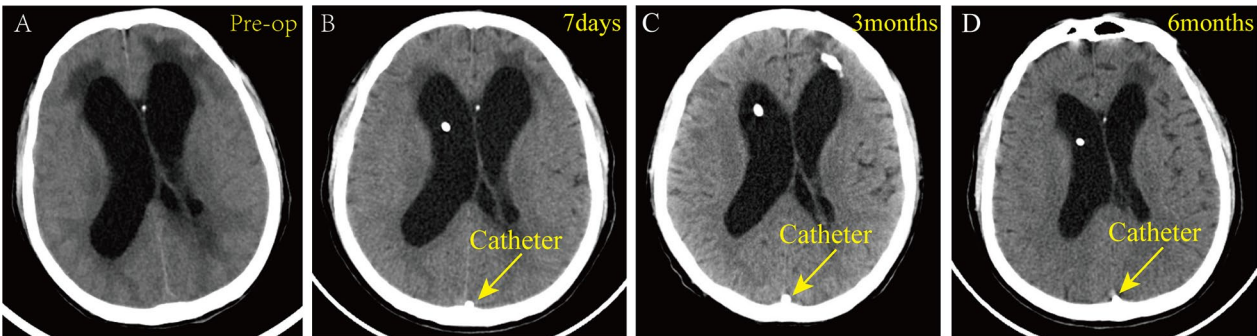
A 50-year-old man was diagnosed with hydrocephalus, and the cause was a brain abscess with intracranial infection (a). The patient had undergone 21 days of lumbar drainage, and an antibiotic was administered to prevent infection. Afterward, the CSFP was continuously maintained above normal, with a content exceeding 0.75 g/L. Moreover, symptoms of infection, such as fever and neck stiffness, had completely disappeared, and four consecutive CSF cultures were negative. We implanted a VSS shunt for the patient. After the operation, considerable improvement in his symptoms was observed, such as hydrocephalus during gait and level of cognitive ability. After VSS shunt system implantation, CT scans at 7 days, 3 months, and 6 months post-procedure revealed diminished dilatation of the lateral ventricles (b–d)
